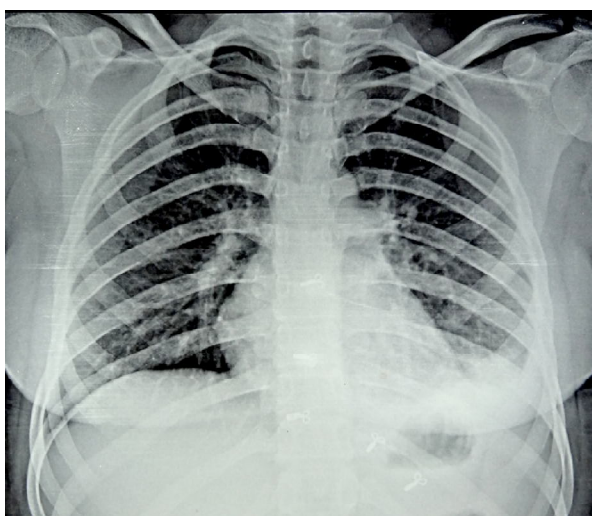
Chest radiograph (postero-anterior view) showing minimal left sided pleural effusion
